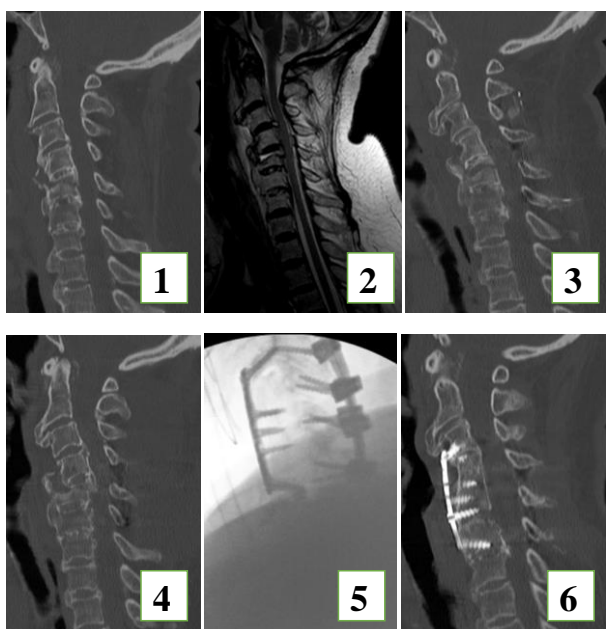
1. CT-C5 transomatic fracture. 2. MRI confirms the C5 transomatic fracture. 3. CT scan after posterior fixation with good fracture alignment. 4. CT in the immediate postoperative period, after dramatic neurological worsening, reveals disassembly of the posterior construction and misalignment of the fracture. 5. Intraoperative images during anterior arthrodesis with tricortical iliac self-graft and plate. 6. Postoperative CT reveals good positioning of the graft and plate.
